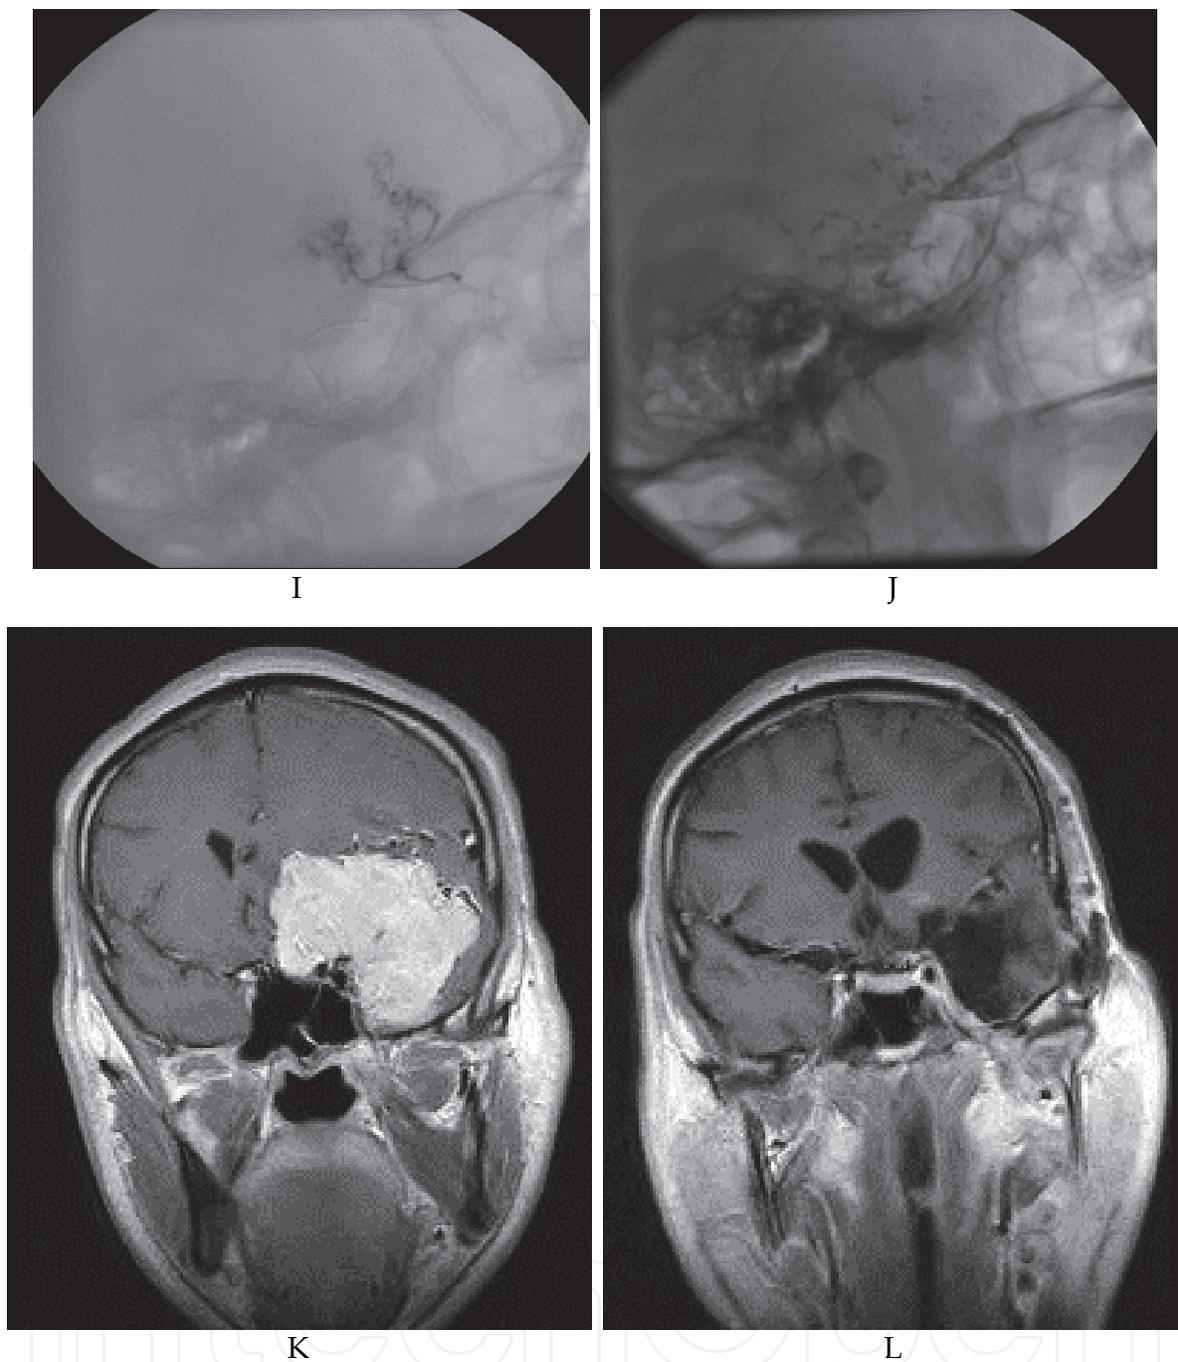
A 48-year-old male with large meningioma of the sphenoid wing. A, B. Selective internal carotid angiogram shows hypervascularized tumor. C, D. The external carotid angiogram demonstrates rich vascularization fed from the middle and accessory meningeal arteries. E. The posterior part of the tumor is supplied by pial feeders arising from posterior circulation. F. Embolization of the tumor was started from hypertrophied pial feeders. G-I. After embolization of the external carotid artery branches (not shown), the ophthalmic artery feeder was catheterized and embolized. J. The lateral view of the skull reveals penetration of radiopaque acrylic glue into the tumor. K. Preoperative MR image of the tumor. L. Postoperative MR image demonstrated total tumor removal in spite of the fact that preoperative embolization was estimated to be only 50 %. The patient suffered from ipsilateral oculomotor palsy after surgery which improved with time.
